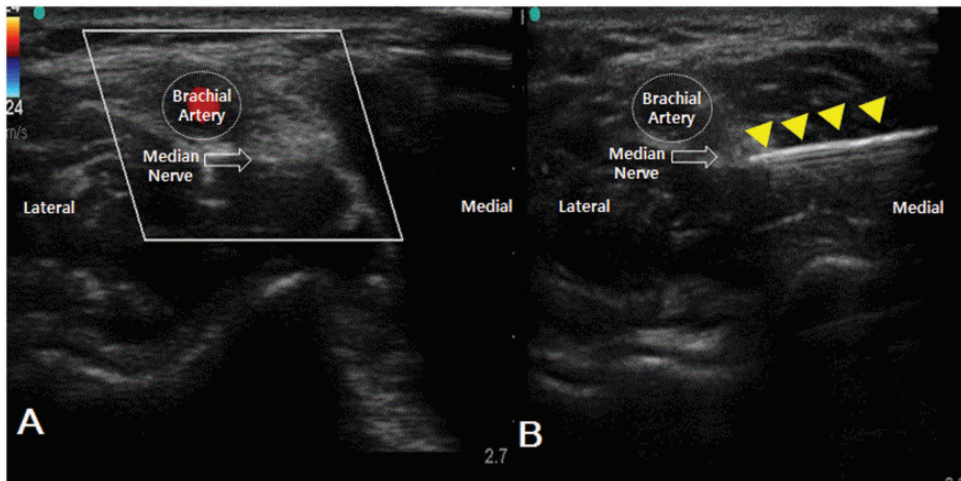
Ultrasound-guided radiofrequency ablation of the median nerve. (a) The brachial artery was examined with color Doppler. (b) The pulsed radiofrequency needle (arrowheads) was placed in the median nerve.
